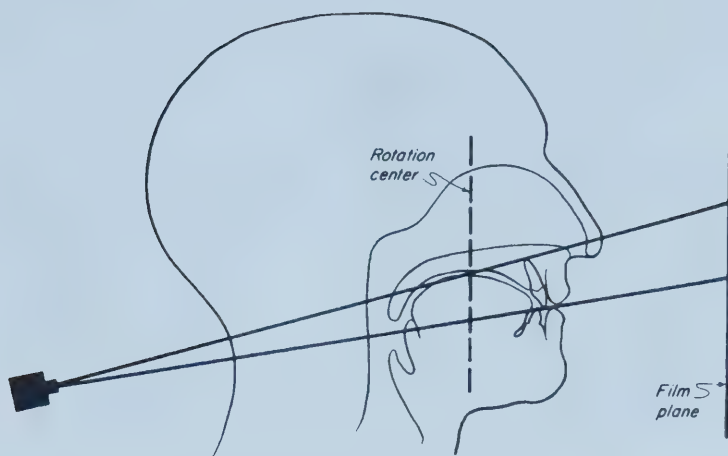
Projection of the X-ray Beam in the Vertical Plane in Panoramic Radiography. The x-ray beam has a slight negative angulation (4 to 7 degrees), allowing it to pass beneath the occipital portion of the skull. (From Langland OE et al. 2002; 9: 202)
